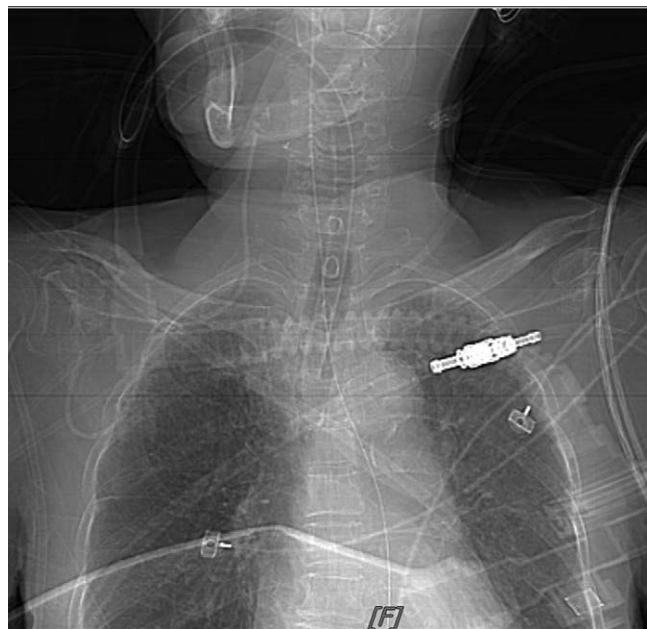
Typical catheter malposition X-ray 1. Patient A, female, 85 years old, cerebral infarction (right temporo-occipital lobe), acute respiratory failure, puncture in subclavian V, catheter placement depth 14 cm, malpositioned location: internal jugular V.
